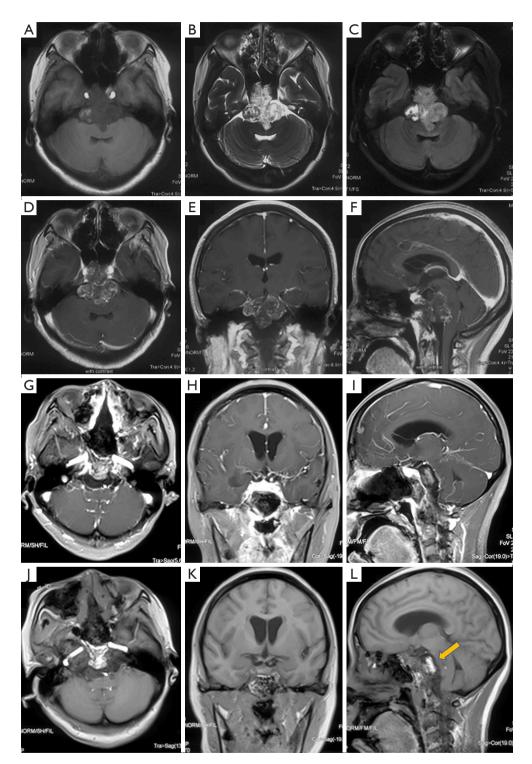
MRI scans of the clival lesion. (A-F) MRI showed a lesion of approximately 46 mm × 44 mm × 37 mm located in the upper clival region. The mass was uniformly enhanced after contrast administration. (G-I) Postoperative enhanced MRI showed total resection of the lesion. (J-L) Postoperative non-enhanced MRI showed fat-packing anterior to the brain stem (arrow). MRI, magnetic resonance imaging.
